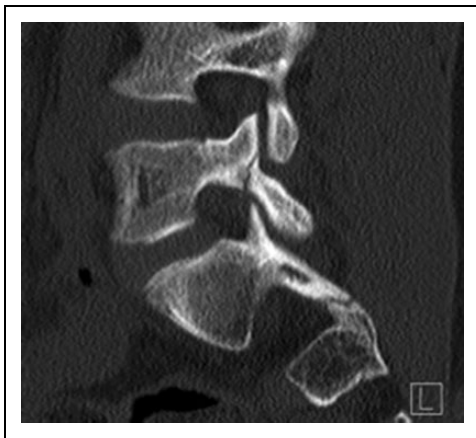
X-ray of the lumbar spine (lateral view) showing a spondylolytic defect.
